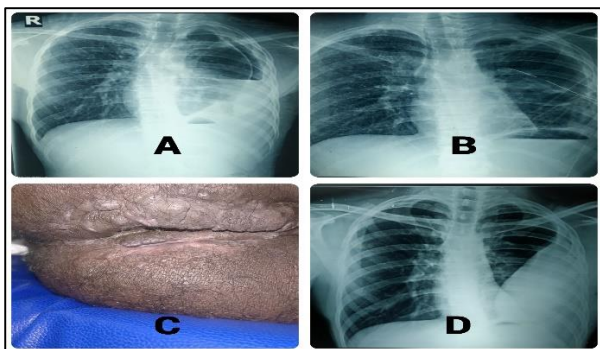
(A-C): Previous X-ray showing hydropneumothorax and lung expansion post ICD insertion. Local examination showing perianal lesion. X ray showing left loculated pleural effusion.
